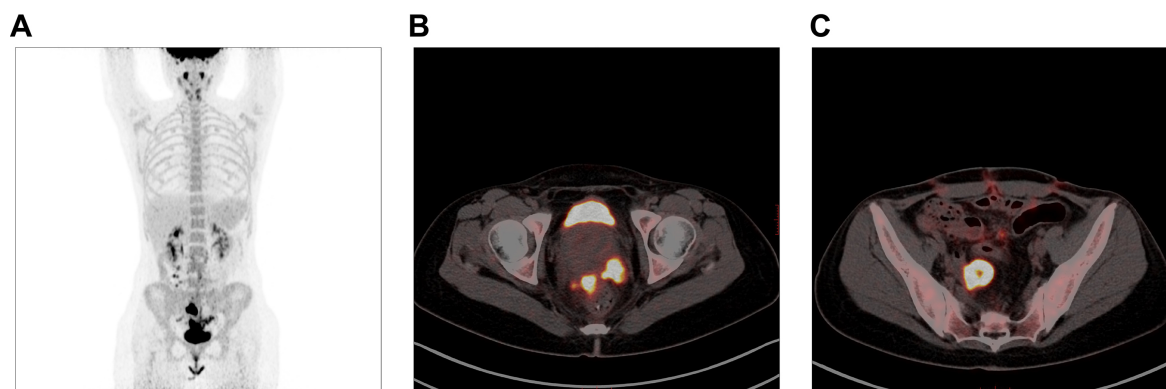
F-18 fluorodeoxyglucose (FDG) positron emission tomography/computed tomography showing increased FDG uptake in the mesentery, retroperitoneum and bilateral pelvic walls. (A) The whole abdomen image. (B,C) Images of the hypogastrium at two axial sections.
